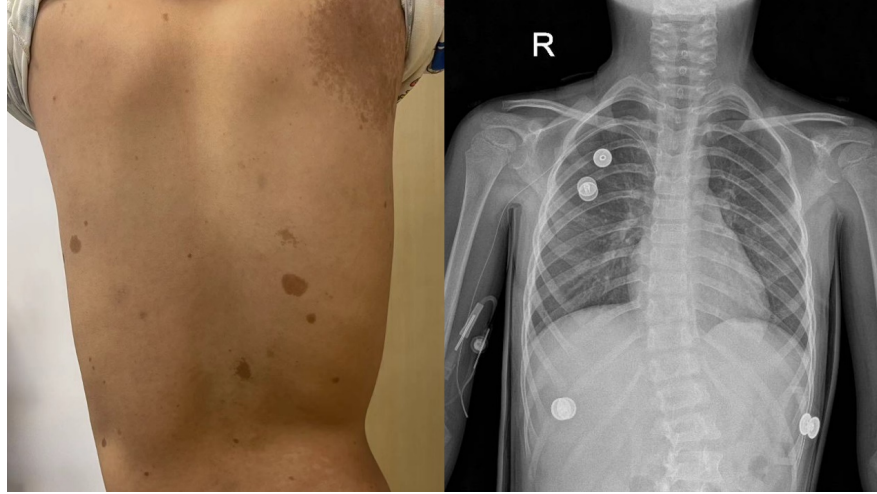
Scoliosis photos and X-ray images of Patient ALL-1
